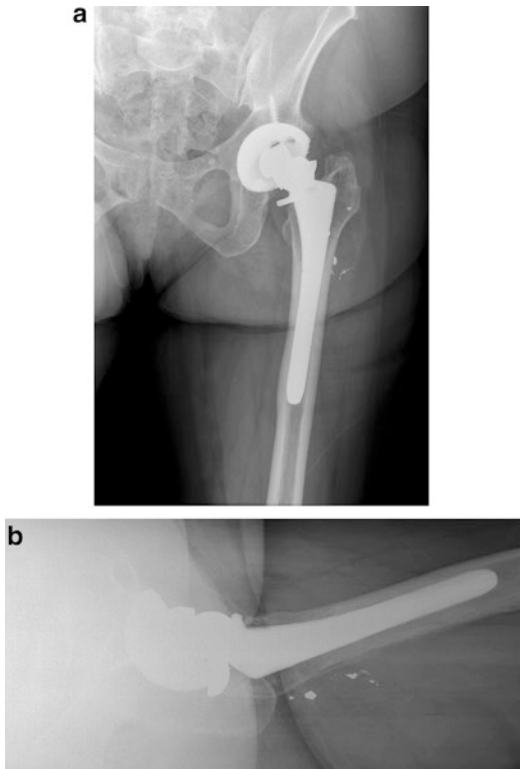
(a) AP radiograph of a broken extensively coated femoral component. Note the subtle discontinuity of the lateral border of the implant. (b) Magnified view of the broken femoral implant. The resultant cantilever bending leads to fatigue fracture of the implant over time
